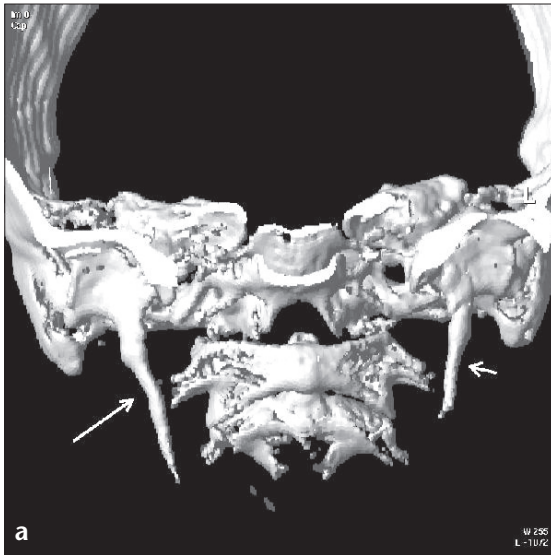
a, b. 3D-CT images of a 36-year-old male. a. Demonstration of bilateral styloid processes from the anterior aspect of the skull (the mandible was excluded). The right styloid process (45.6 mm) (*long arrow*) is significantly longer than the left (37 mm) (*short arrow*). b. Inferior-oblique view of the same case shows the right styloid process (*long white arrow*), the hyoid bone (*black arrows*), and the stylohyoid ligament calcification (*short white arrows*).
